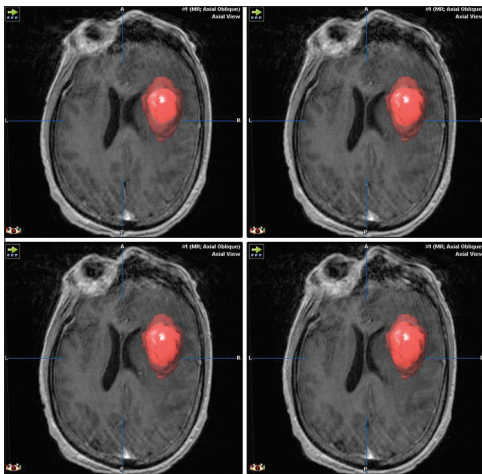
Volumetric MRI reconstruction posttreatment day seven
